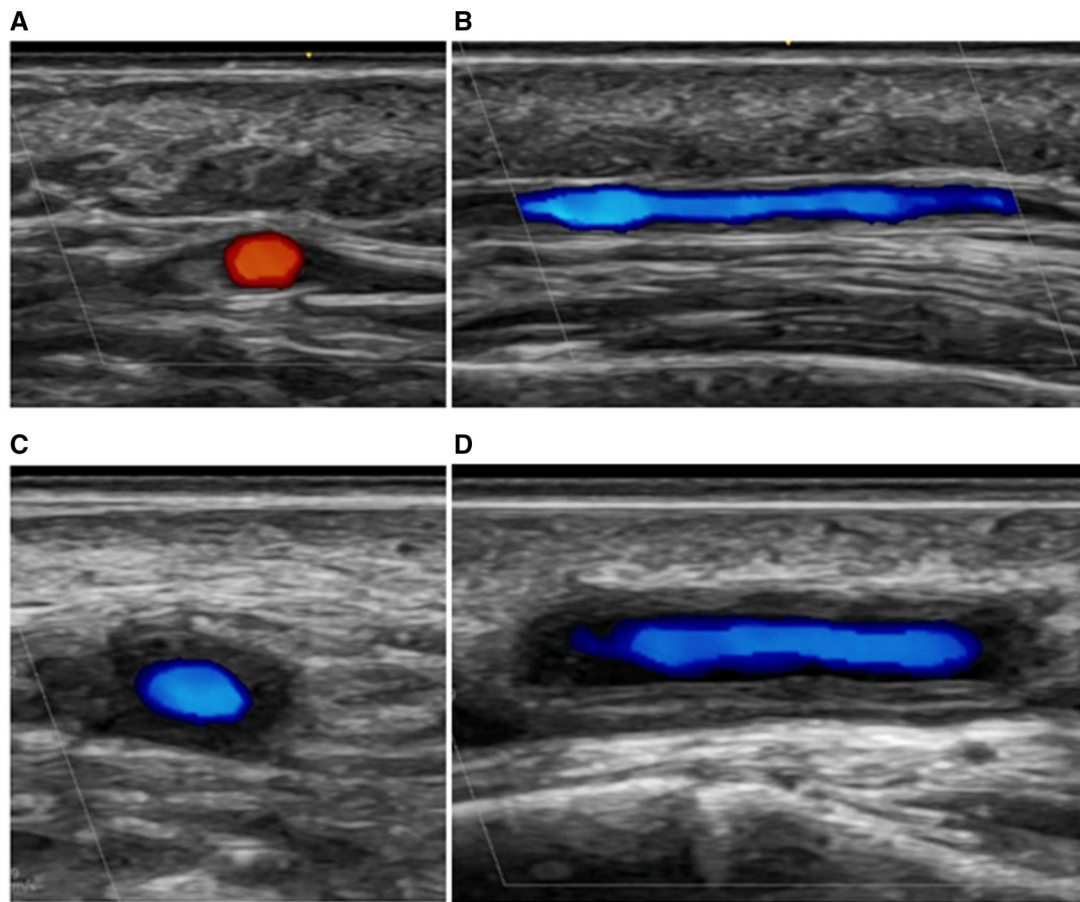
Ultrasound images of the temporal artery adapted from Hernández *et al.* [71]. This study is published under a CC-BY Creative Commons license. A normal superficial temporal artery in (A) transverse and (B) longitudinal view. A hypoechoic, homogeneous thickening of the superficial temporal artery—the halo sign—in (C) transverse and (D) longitudinal view
